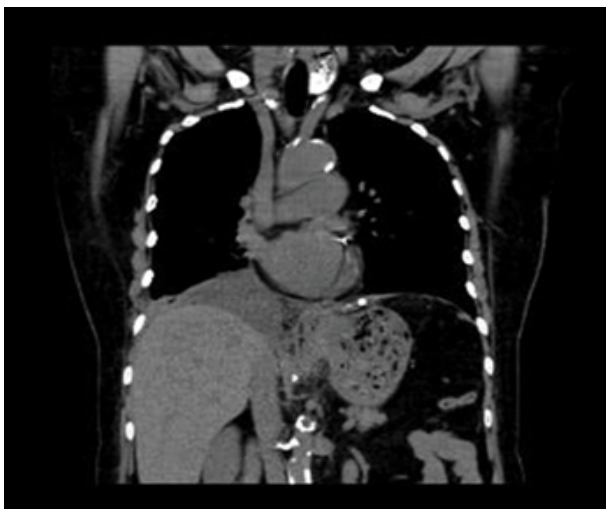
Chest CT, diaphragmatic hernia disappears and diaphragm is intact.
